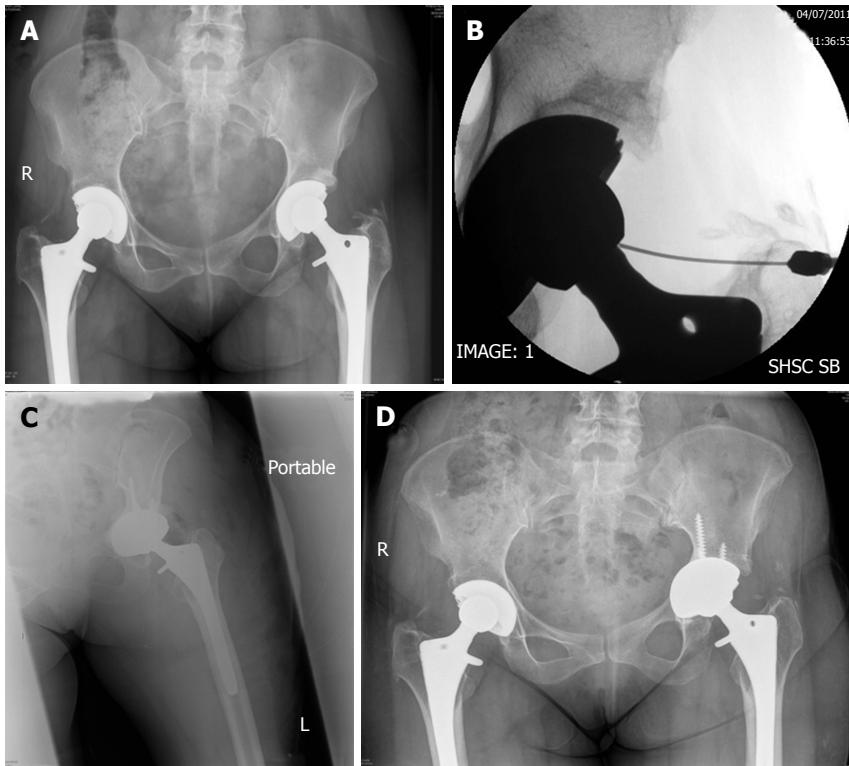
Case demonstration. A: Preoperative X-ray; B: Hip aspiration; C: Post operative X-ray; D: Five-year follow-up.
